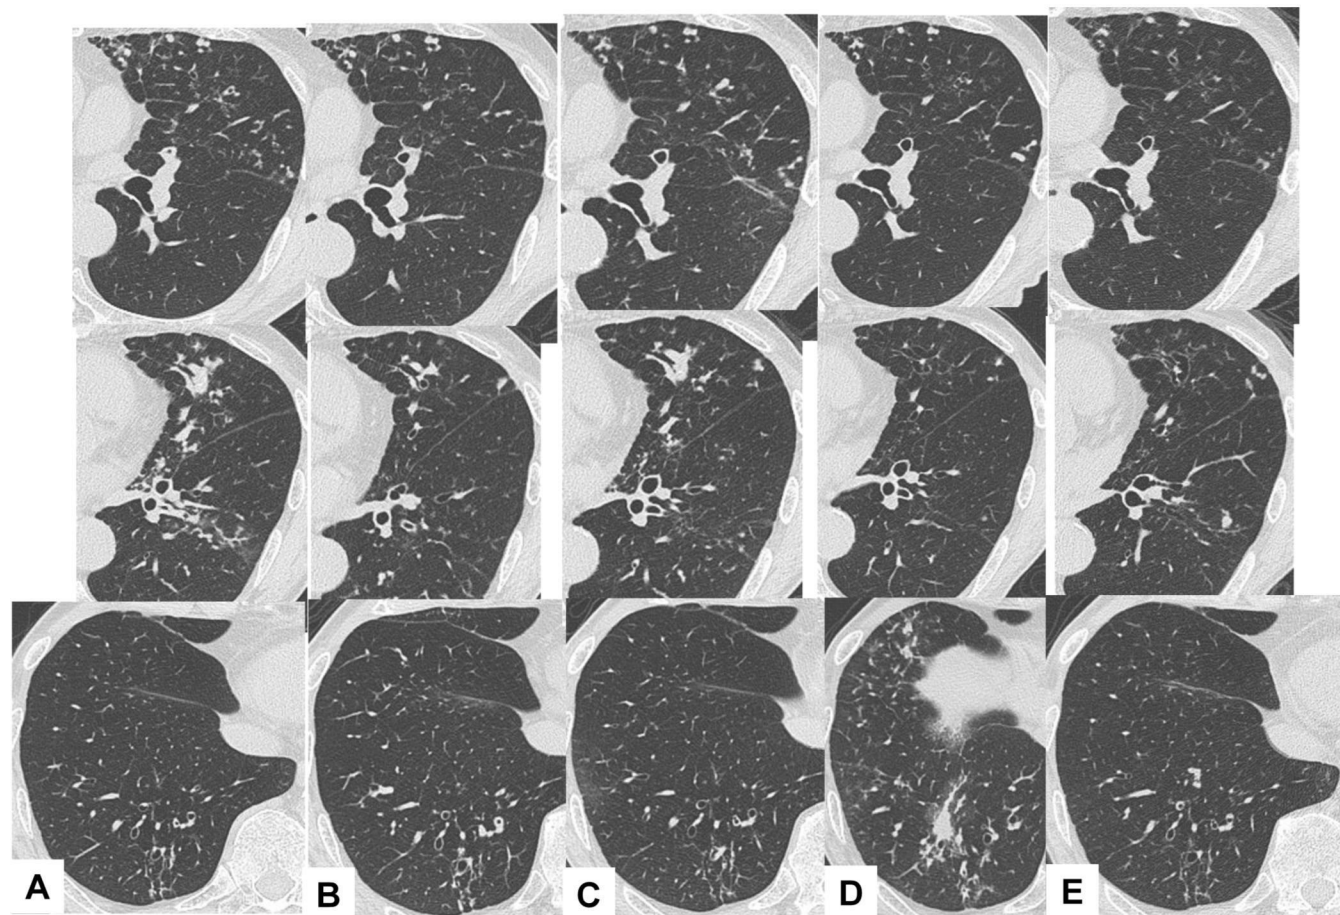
CT revealing transition of ABPA and MAC-LD. (A) Chest CT at admission before the initiation of itraconazole (0 months). Chest CT revealed central bronchiectasis with mucous plugs and a small nodular shadow in the left upper lobe. (B) Chest CT before the initiation of clarithromycin, rifampicin and ethambutol (5 months). Chest CT revealed disappearance of the mucous plugs and no change in small nodular shadows in the left upper lobe. (C) Chest CT before the reinitiation of itraconazole (12 months). Chest CT revealed recurrence of the mucous plugs and no change in small nodular shadows in the left upper lobe. (D) Chest CT at termination of antimicrobial therapy for MAC-LD (24 months). Chest CT revealed the appearance of mucous plugs in the right lower lobe and no change in small nodular shadows in the left upper lobe. (E) Chest CT at 14 months after the termination of antimicrobial therapy for MAC-LD (38 months). Chest CT revealed disappearance of the mucous plugs in the right lower lobe and no change in small nodular shadows in the left upper lobe. ABPA, allergic bronchopulmonary aspergillosis; MAC-LD, *Mycobacterium avium* complex lung disease.
